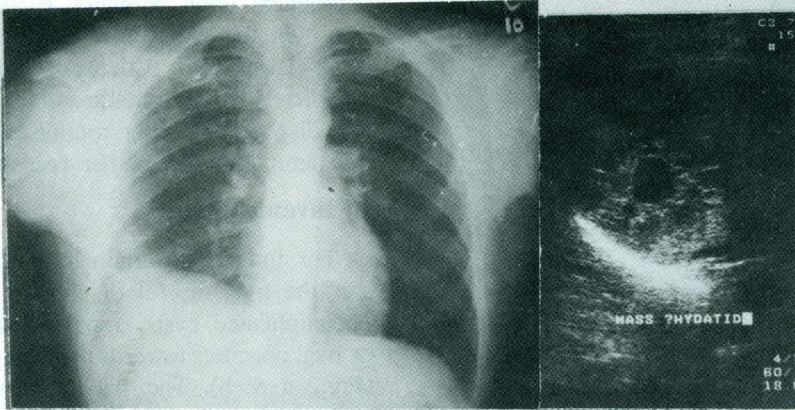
(a & b). a-Plain X-ray chest showing elevated right diaphragmatic copula. b-Ultrasonography abdomen of the same patient demonstrating "liver dome" hydatid cyst.
